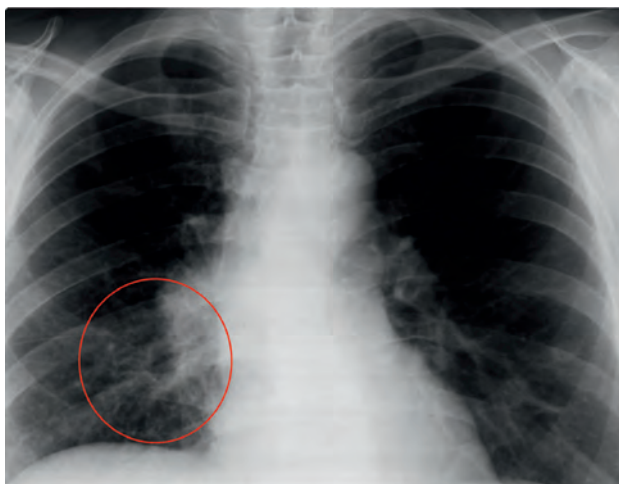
Chest x-ray (December 29, 2005)
